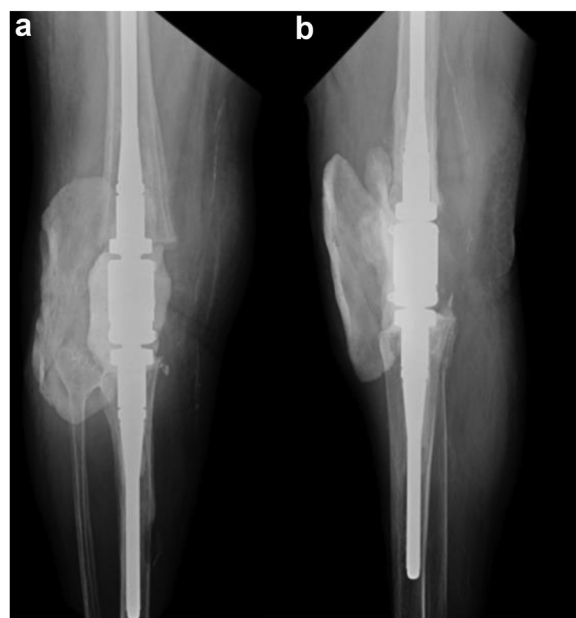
First reoperation for a patient with superficial infection. Postoperative radiographs after superficial irrigation, debridement, and placement of antibiotic cement with retainment of the modular knee arthrodesis (MKA).
